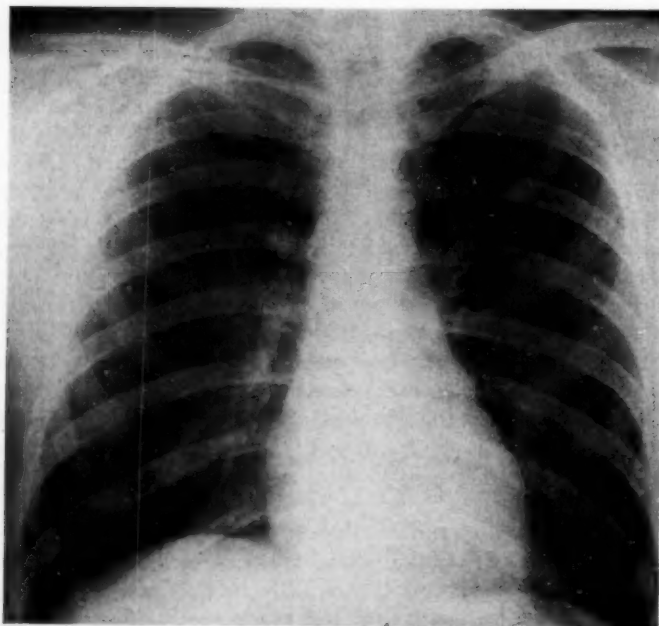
Normal-appearing roentgenogram of the chest in earlier part of illness.
